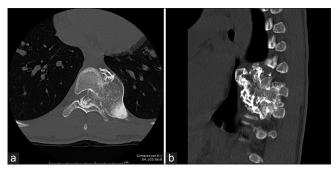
Preoperative noncontrast computed tomographic scan in both axial (a) and sagittal (b) dimensions demonstrating the osteochondroma with significant encroachment within the spinal canal
